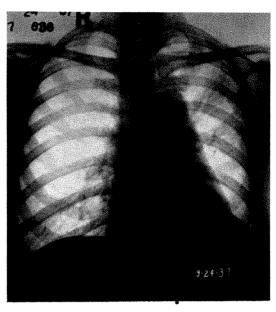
Roentgenogram of chest of Case XIX, three months after irradiation was started and one month after last treatment. Note radiation changes in upper left chest, with displacement of heart, mediastinum and trachea to left.
